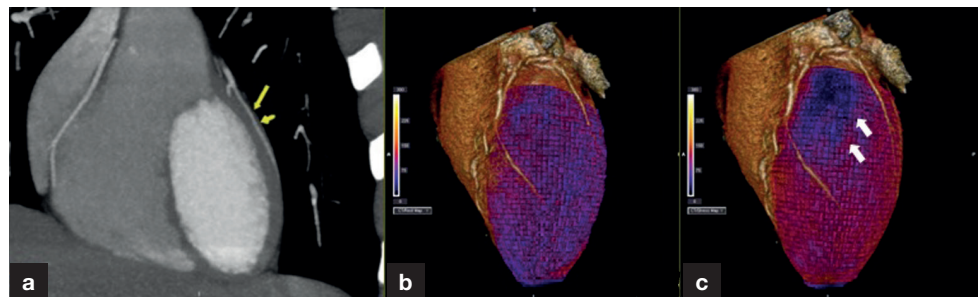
a. Curved multiplanar reconstructed computed tomography angiography showing a long segment superficial myocardial bridge (arrows) in the first diagonal branch (D1) of the left anterior descending artery. b. Normal perfusion deficit in polar map fused 3D volume-rendering image of rest perfusion study derived from his initial coronary computed tomography angiography. c. Note the perfusion deficit (arrows) in basal anterolateral wall of the left ventricle in perfusion polar map fused 3D volume-rendering images of the adenosine stress myocardial computed tomography perfusion study.
